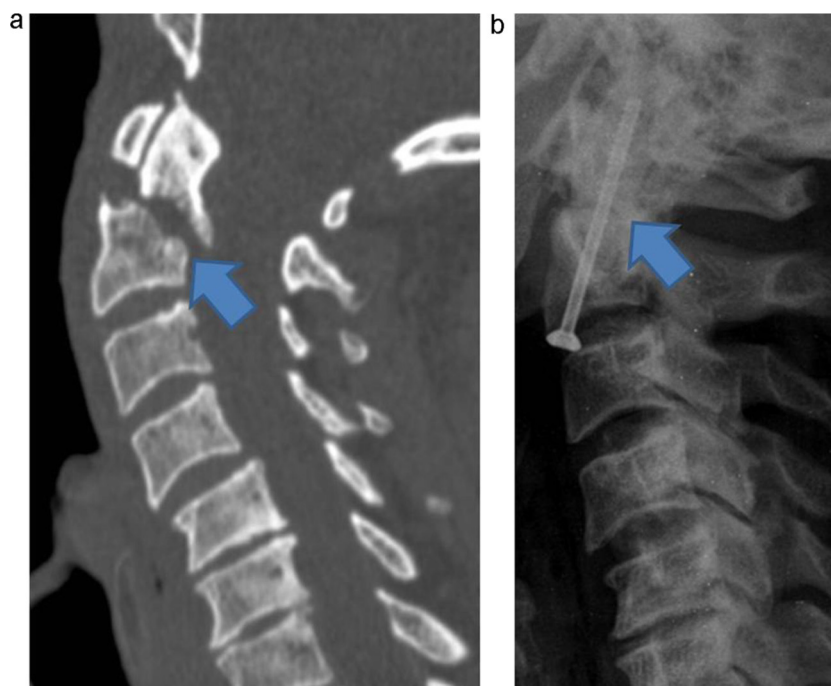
(A) CT preoperative control in post-traumatic type 2 odontoid broken fracture. (B) XR post-operative control: screw positioning with the realignment of the bone fragments.
